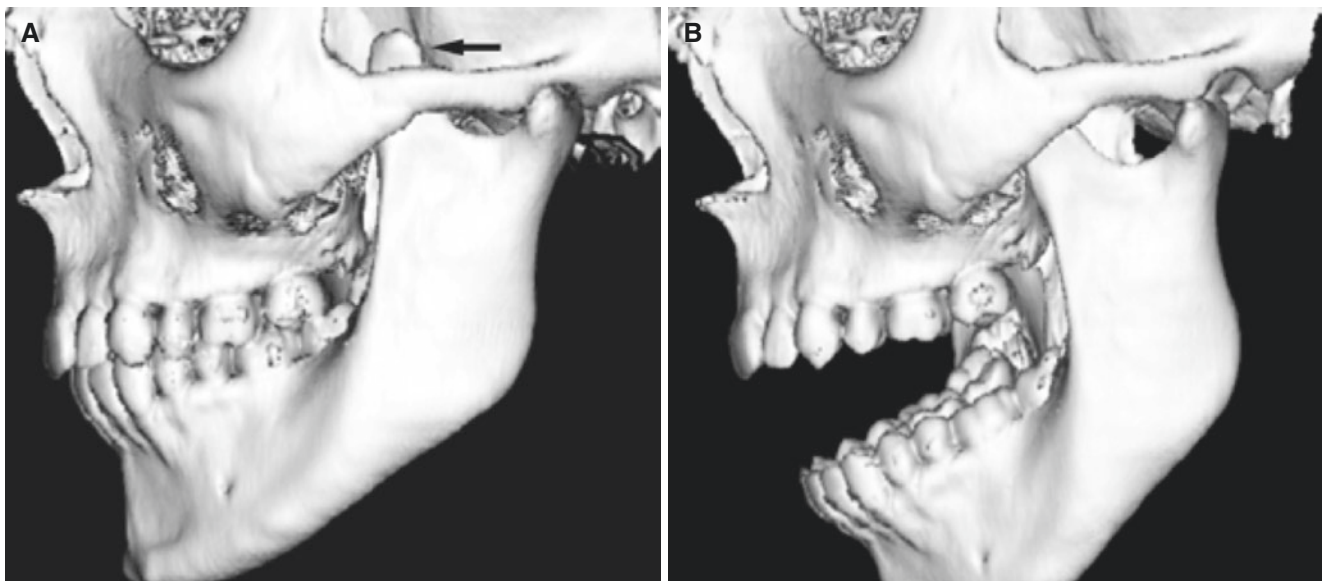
Coronoid hyperplasia. (A) Closed-mouth and (B) open-mouth 3D CT images show enlarged coronoid process (*arrow*), not allowing normal motion of mandible. See also Fig. 9.33c
